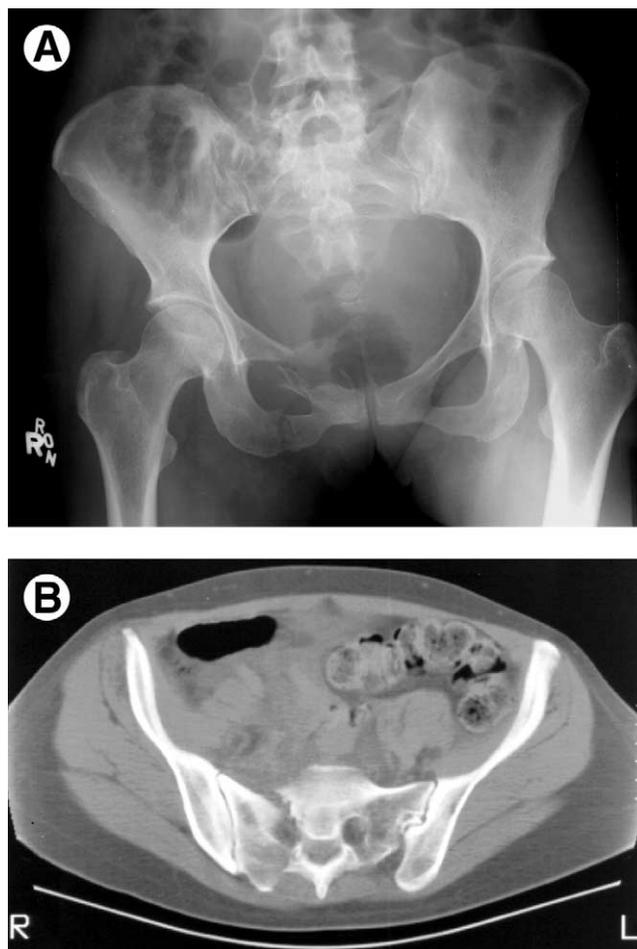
(A) The right superior and inferior pubic rami and right sacral ala are disrupted, and the right femoral head and acetabulum lie cephalad compared with the left. (B) The sacral fracture is better seen on CT. Vertical shear injury.
